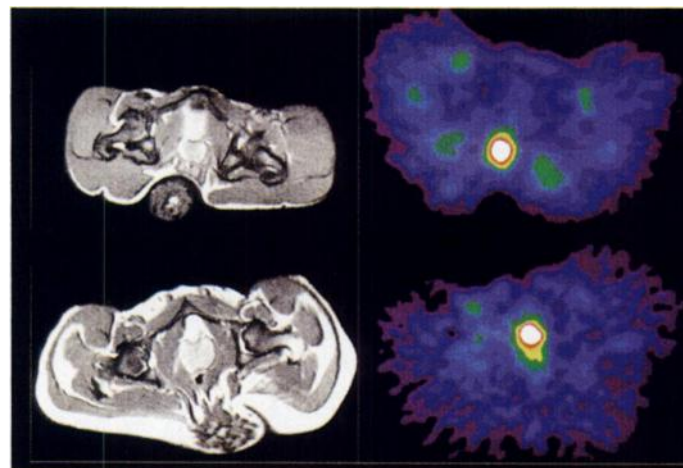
Comparison of transaxial images obtained with MRI (left, gray scale) to those obtained 60 min after injection of compound I with PETT VI (right, color). Upper images are of Baboon 2; lower are of Baboon 1. The medially located medium gray area in the MR images and the white area of increased radioactivity in the PET images is the prostate.
